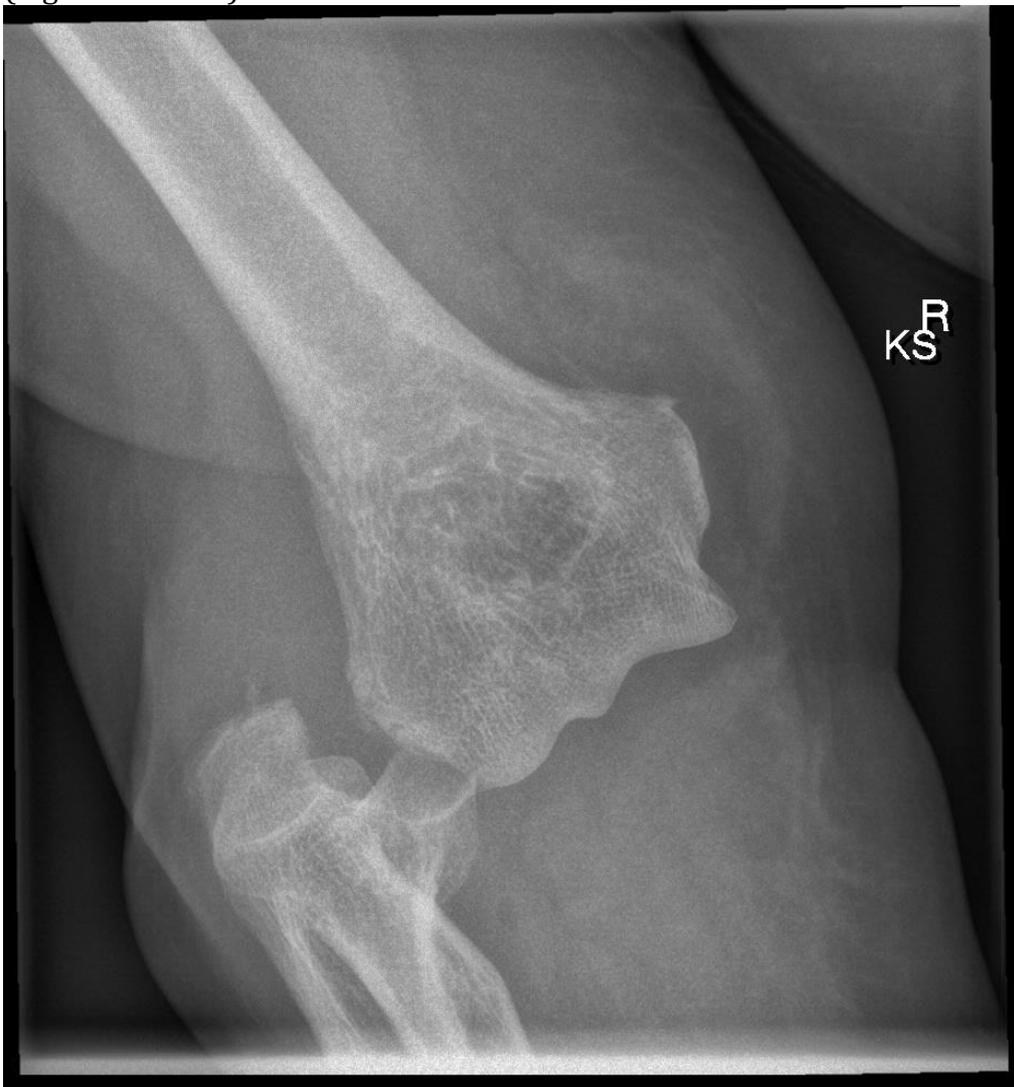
X-Ray AP view of posterolateral elbow dislocation.
